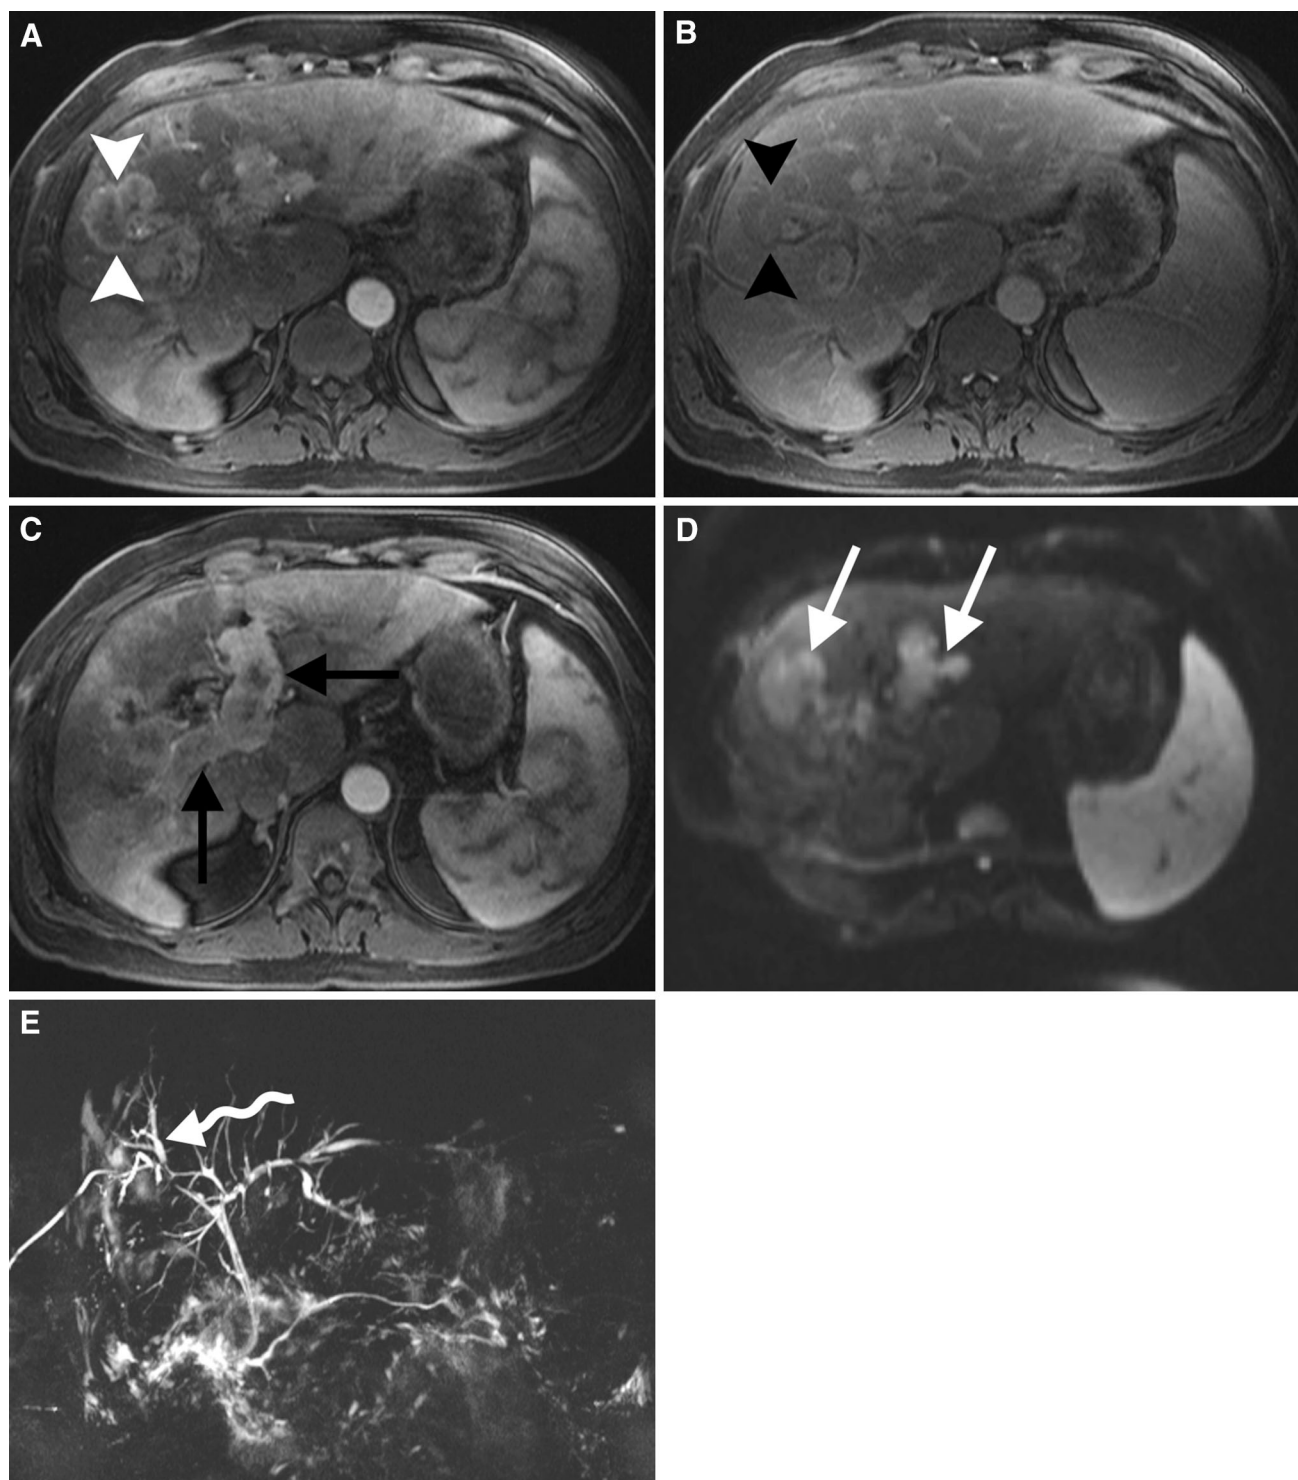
CHC in a 49-year-old man with chronic hepatitis B, with mixed imaging features. A, B Axial T1 VIBE contrast-enhanced arterial and 5-min-delayed MRI demonstrates a peripherally enhancing mass (*white arrowheads*) with delayed washout (*black arrowheads*). C Axial T1 VIBE contrast-enhanced arterial phase MRI demonstrates enhancing tumor
